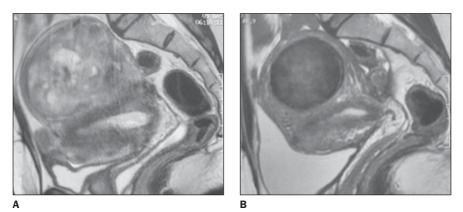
Pre-embolization (A) and postembolization magnetic resonance imaging (sagittal view) demonstrating complete ischemia of subserous and significant decrease in uterine volume.
